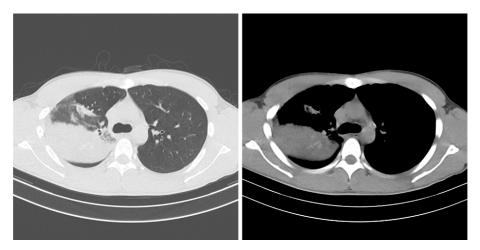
High-resolution chest computed tomography image revealed central bronchiectasis with a mucus plug in the right upper lobe.
